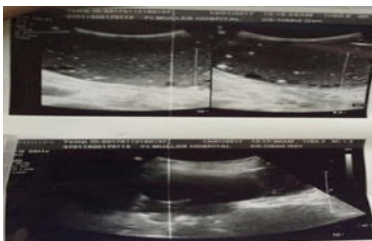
Ultrasonography image of hydatid cyst
